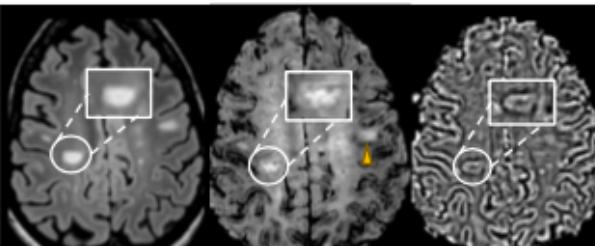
Axial Wave-SPACE-FLAIR (left), Wave-SWI (middle), and phase images (right) in a patient with confirmed MS showing the presence of paramagnetic rims corresponding to lesions visible on FLAIR (highlighted). A lesion with a central vein sign can be seen in the same Wave-SWI sequence (arrowhead).
